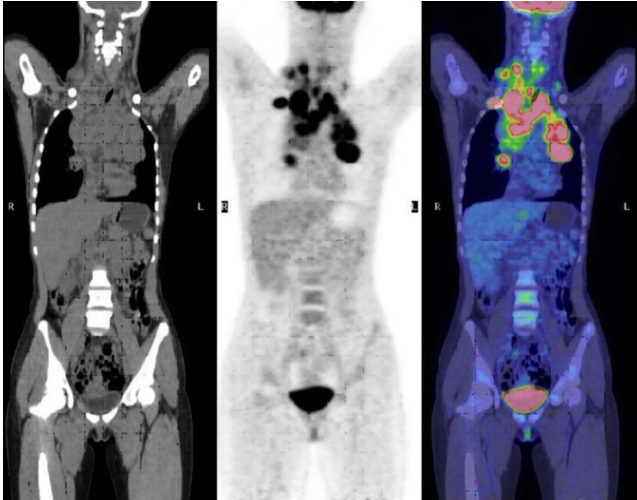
14-year-old girl with nonossifying fibroma. Multiple enlarged mediastinal and right cervical lymph nodes are noted on CT (left), with increased uptake on coronal F18-FDG PET (middle) and F18-FDG PET/CT fusion image (right)
